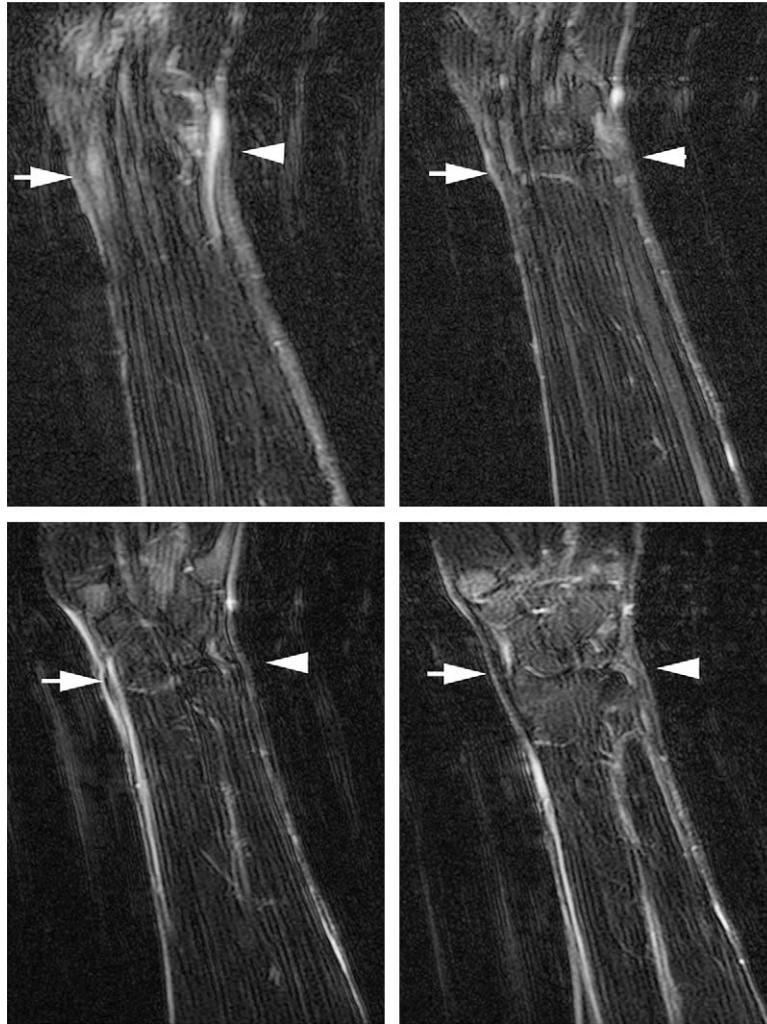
Magnetic resonance imaging scan with coronal views (T2 fat suppression) of the patient's distal left upper extremity 12 months after treatment with etanercept. There is decreased signal intensity of the flexor carpi radialis (*arrow*) and extensor carpi ulnaris (*arrowhead*) tendons.
